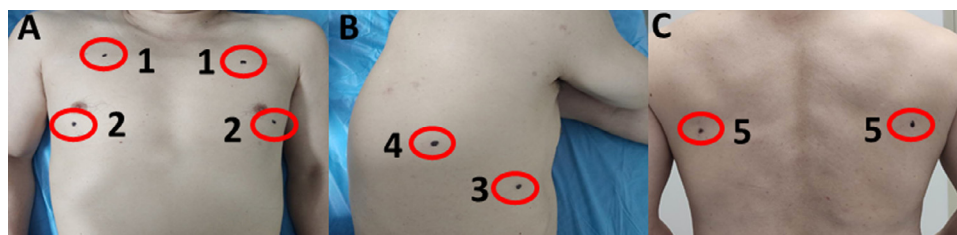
Bedside lung ultrasound in emergency (BLUE)-plus protocol. (A) Upper blue point (1), lower blue point (2); (B) phrenic point (3); posterolateral alveolar and/or pleural syndrome point (PLAPS-point) (4); (C) posterior blue point (5).
